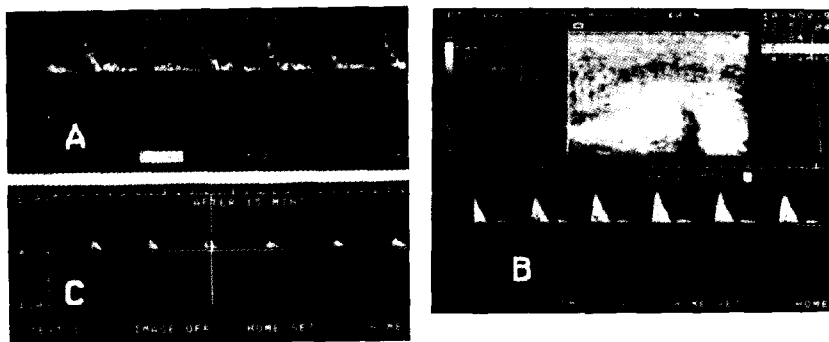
value of extending the doppler test to 20-30 min. A) Normal systolic peak velocity and diastolic flow of 9 cm/sec. B) 15 min. later, diastolic flow became 2 cm/sec. C) Full erection with disappearance of diastolic flow.
